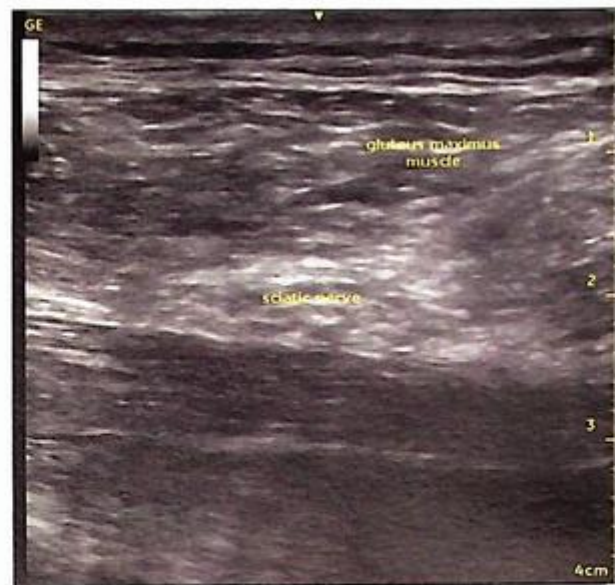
Ultrasound still of sciatic nerve block.
